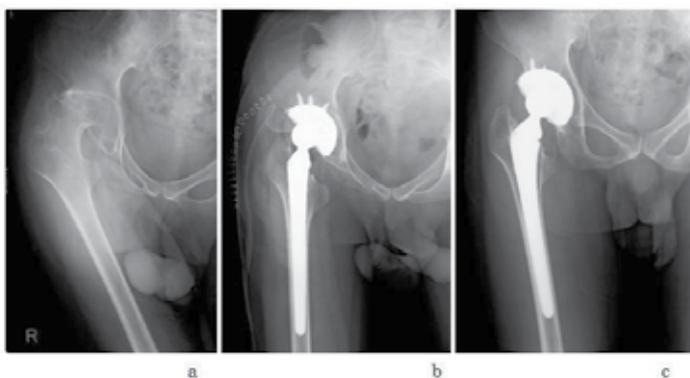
A 23-year-old hemophilia A patient with inhibitor. HCV is positive. Severe hemophilic arthropathy of the right hip. His back pain and tilted pelvis are improved after surgery. (a): pre-operative radiography; (b) just operative radiography (c) at five year radiography
